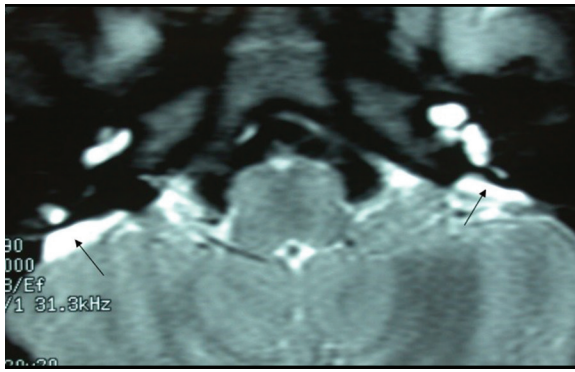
Axial T2-weighted fat-saturated MRI in a 4-year-old girl with nonsyndromic EVA; black arrows point to bilaterally enlarged endolymphatic sacs
